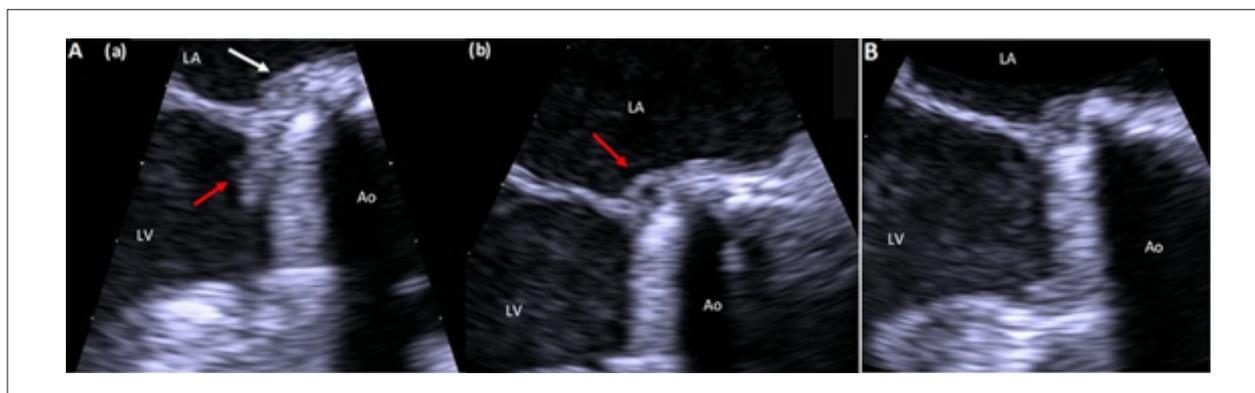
2A) Transesophageal echocardiogram, midesophageal long-axis aortic valve plane. (a) Vegetation (red arrow) and inflammatory infiltrate (white arrow). (b) Annular abscess (red arrow). Ao: ascending aorta; LA: left atrium; LV: left ventricle. 2B) Transesophageal echocardiogram at discharge, midesophageal long-axis aortic valve plane. No vegetation or abscess visible. Ao: ascending aorta; LA: left atrium; LV: left ventricle.
